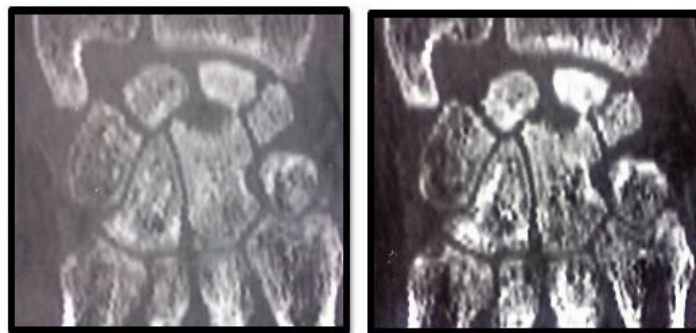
Right wrist CT- Scan three weeks after the initial trauma showing the capitate head fracture.
